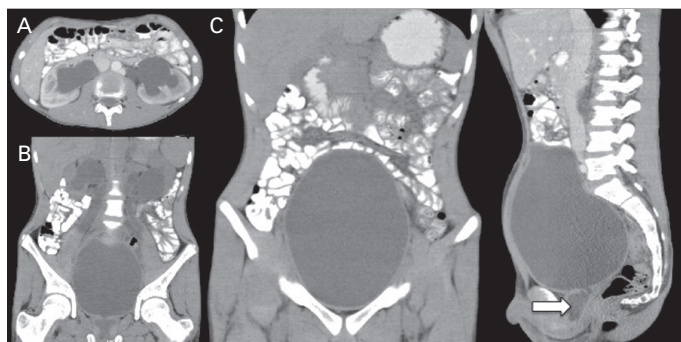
Contrast enhanced computed tomography scan of the abdomen and pelvis. (A) bilateral hydronephrosis; (B) hydroureter and dilated posterior urethra ending abruptly; (C) bladder distention; (D) bladder and posterior urethral dilatation (arrow).
